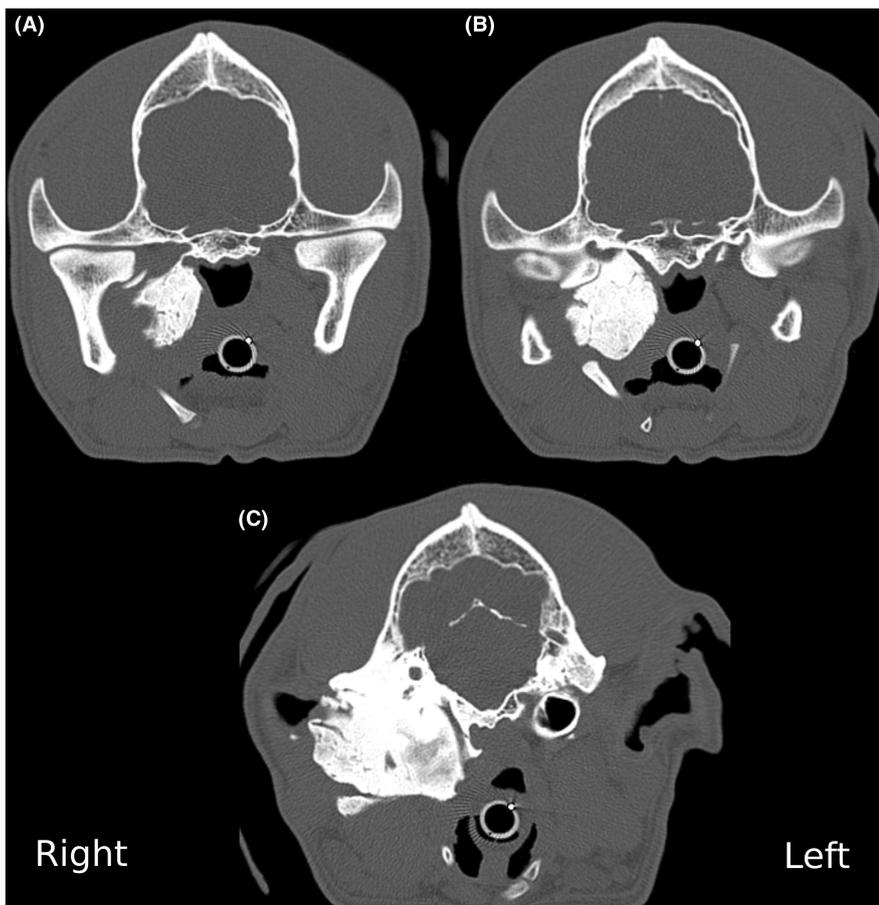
Skull CT 6 months after diagnosis, at the same level of the images of Figure 1. Absence of the previously described thickening and hyperattenuation of the temporal, parietal, and occipital bones. The mass-like lesion at the region of the temporomandibular joint has a more compacted appearance.
